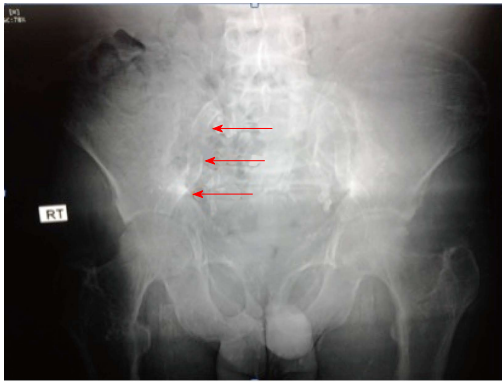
Plain X-ray of the pelvis in hemodialysis patient for 52 mo showing extensive calcification of the right common and external iliac arteries (arrows).
